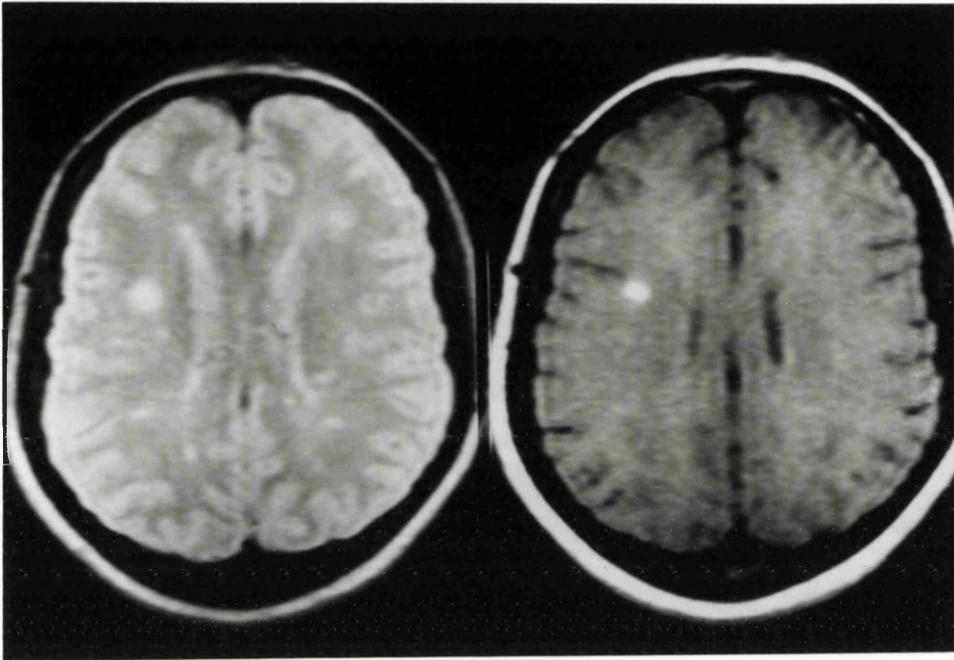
MRI of the brain with and without contrast enhancement
